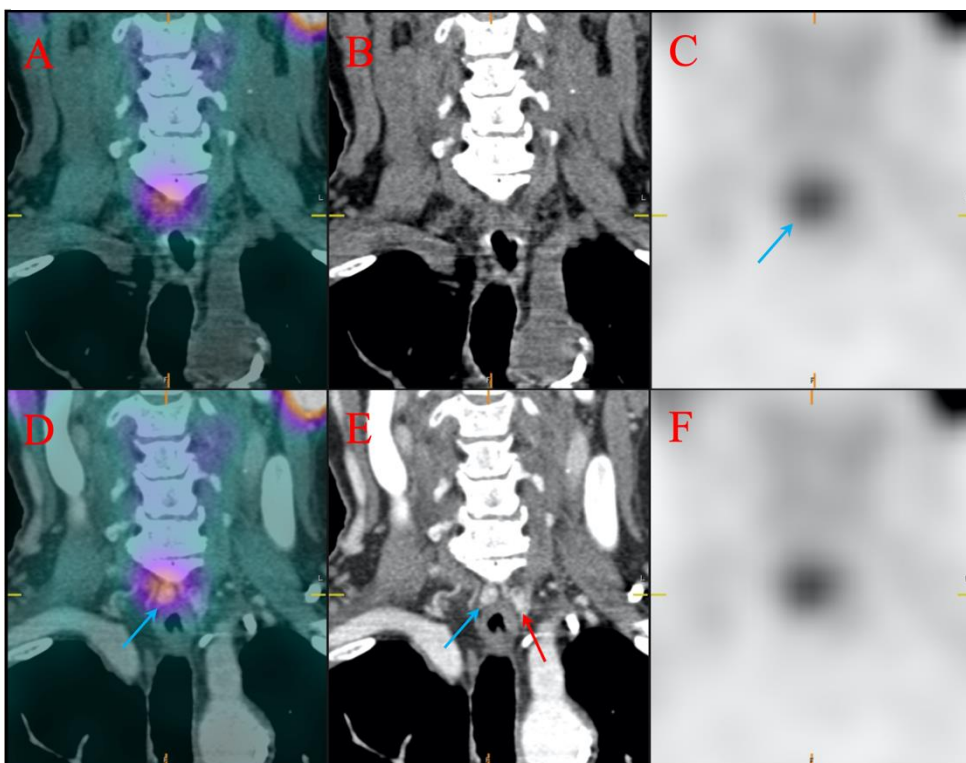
A patient with MGD with one paraesophageal PTA on each side. Only one focal sestamibi uptake can be discriminated (blue arrow in C and D). However, on contrast-enhanced CT images two enhancing soft tissue nodules are found (blue and red arrow in E), both corresponding to parathyroid adenomas. The non-enhanced phase (B) does not contribute to detection.
